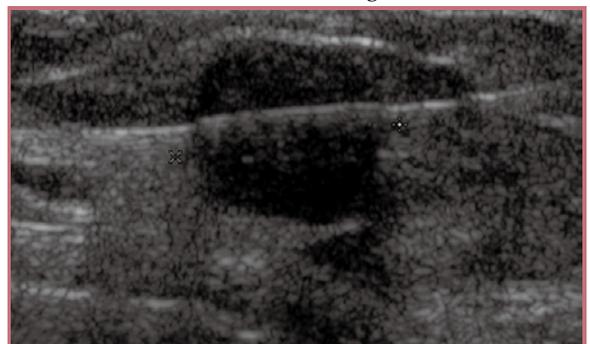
ultrasound guided hookwire insertion.
